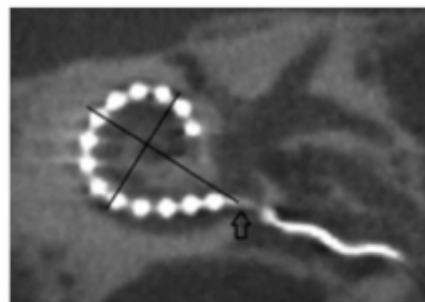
Postoperative cone beam CT (CBCT) imaging reformatted in the oblique coronal plane demonstrating the intracochlear electrode array (Connor et al., 2018)
